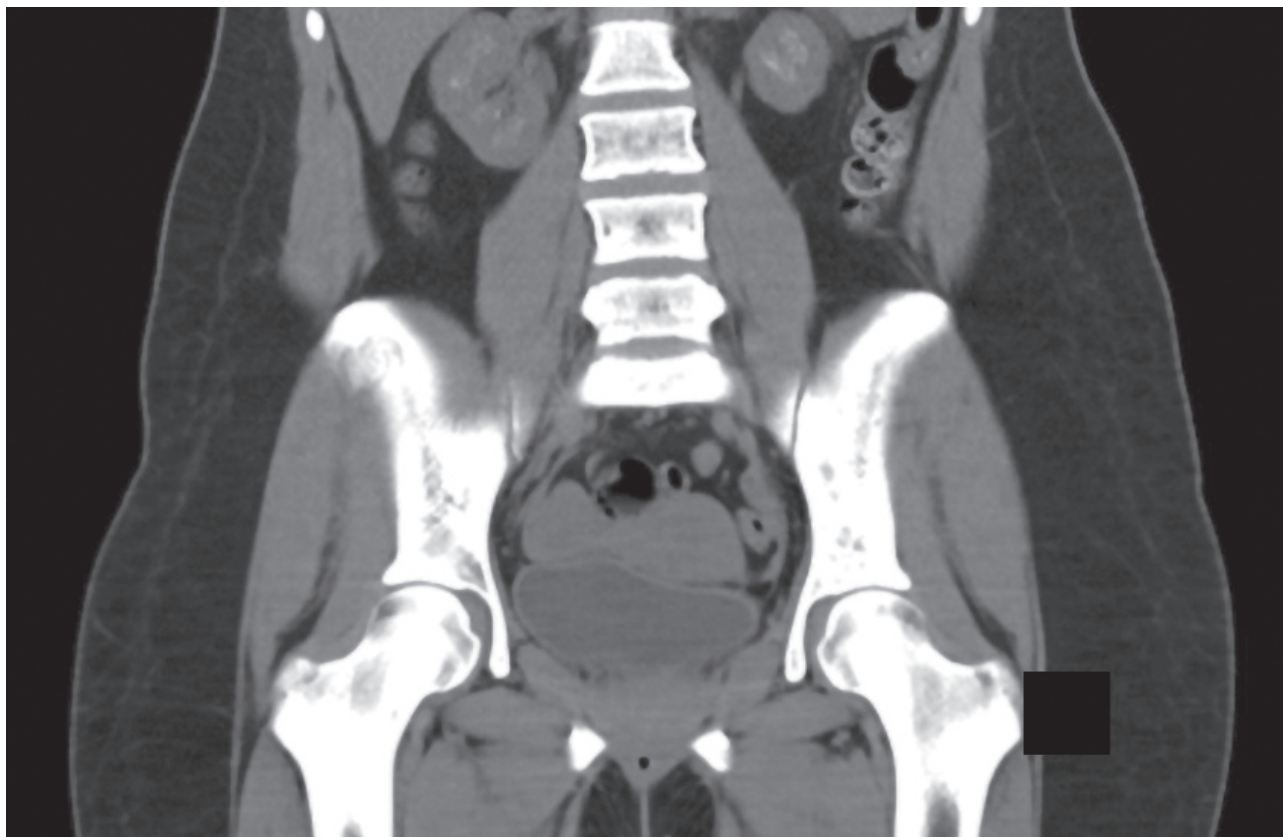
Hip CT (two-month follow-up)
